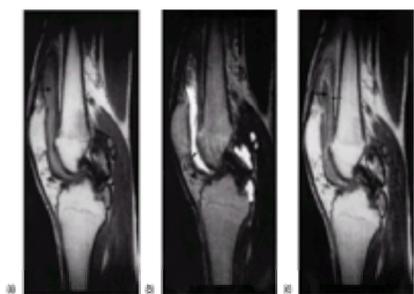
Haemophilic arthropathy affecting the knee in a 14-year-old boy. (a) T_1 -weighted MR image shows joint effusion (arrow) and synovial haemosiderin deposition (arrowhead). (b) T_2 -weighted MR image shows articular surfaces with an arthrographic-like appearance (arrow). Haemosiderin deposition has a decreased signal (arrowhead). (c) Enhanced T_1 -weighted MR image shows enhancement in the proliferative synovium (arrow) and allows a reliable distinction between active synovium and joint effusion (long arrow).
